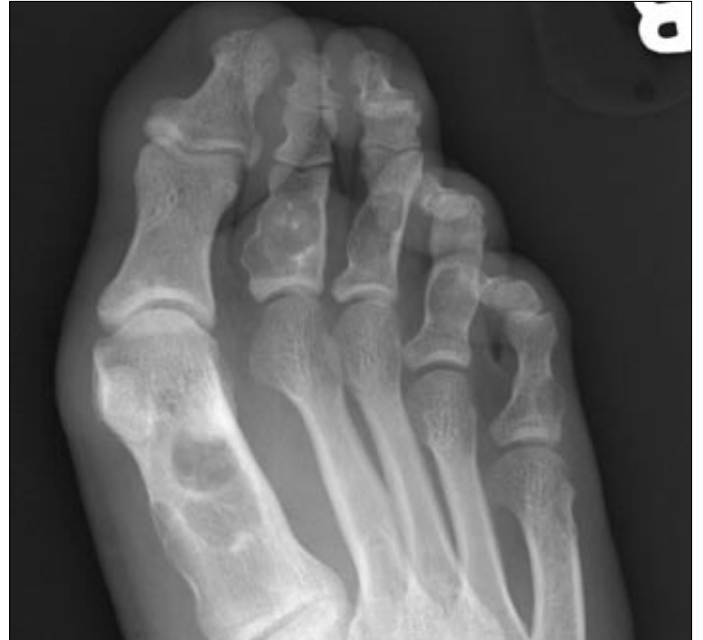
Anteroposterior radiograph of the foot demonstrates similar lesions in the first metatarsal and in multiple phalanges.
